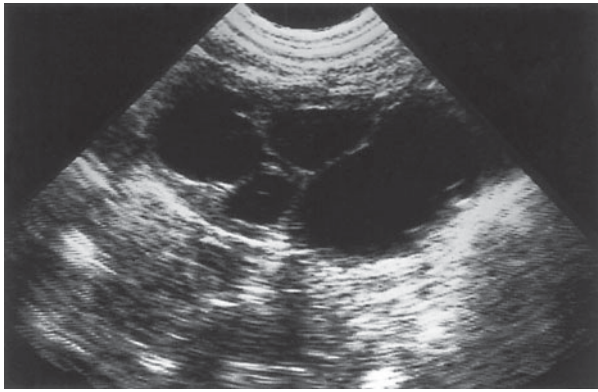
Newborn with prenatal diagnosis of left hydronephrosis. (a) Ultrasound of left kidney taken shortly after birth. Normal study. Echolucent areas (arrow) in renal cortex are pyramids (normal finding). (b) Same patient. Ultrasound of left kidney at 6 weeks shows grade 4 hydronephrosis.
